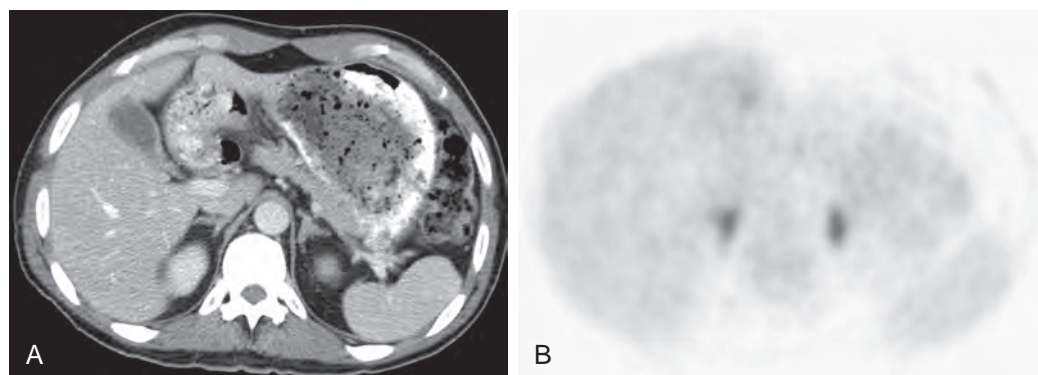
Adrenal lymphoma. A. Contrast-enhanced CT demonstrates essentially normal-appearing bilateral adrenal glands. B. PET scan demonstrates increased FDG avidity in the glands bilaterally (arrow indicating right uptake). Percutaneous biopsy of the left adrenal gland confirmed lymphoma.
